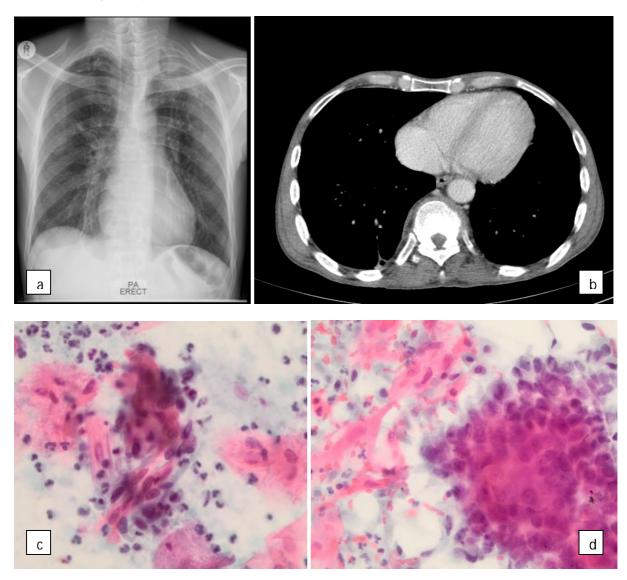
Left, apical mass adjacent to the mediastinum with infiltration of vertebrae and lymphadenopathy on chest X-ray (a) and CT (b). Sputum - malignant.
